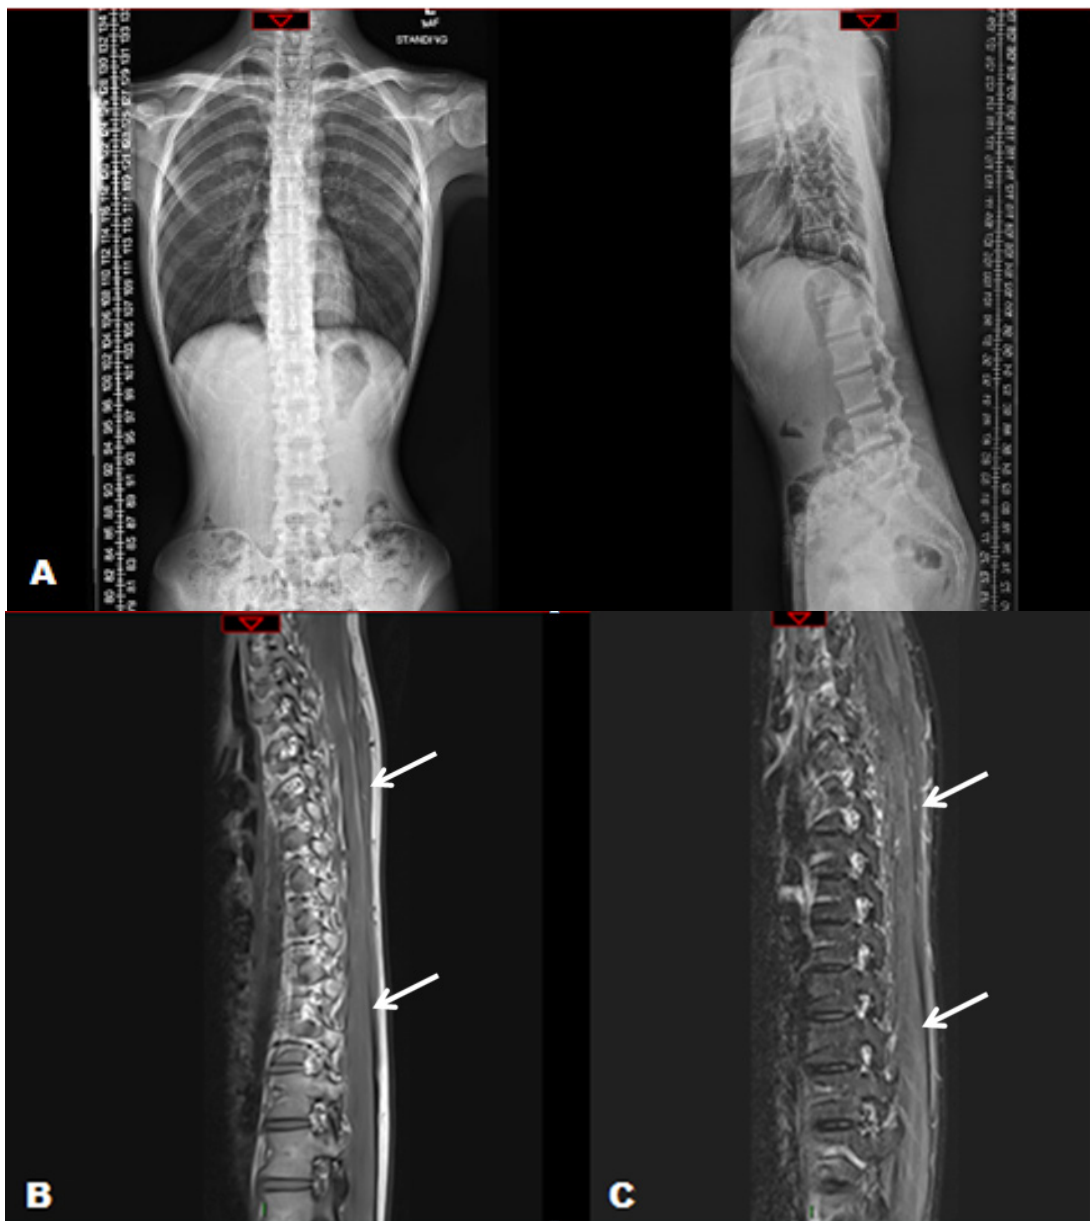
Anterior-Posterior (AP) and lateral X-ray of the spine (A) showing a straight spine with only minimal scoliosis and no kyphosis or lordosis. MRI sagittal view of the thoracolumbar spine (B) T1-weighted and (C) Short Tau Inversion Recovery (STIR) sequences showed relatively preserved paravertebral muscles (white arrows) without fat infiltration or inflammation.
